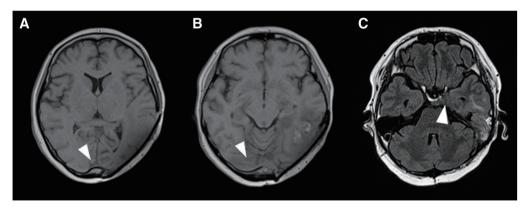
MRI after MT revealed the disappearance of the hyper-intensities in the superior sagittal sinus and right transverse sinus on T1-weighted imaging (arrowhead) (A, B); however, FLAIR showed a new tumor in the left cavernous sinus (arrowhead) (C). MT, mechanical thrombectomy
